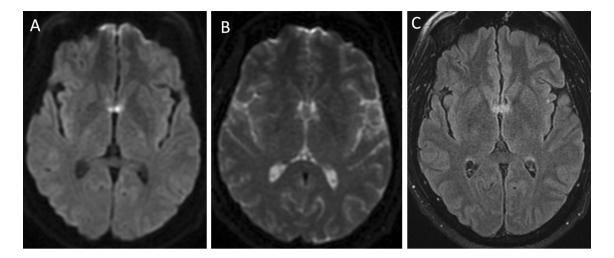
MRI brain two days post symptom onset. (A) DWI, (B) ADC and (C) T2 FLAIR
